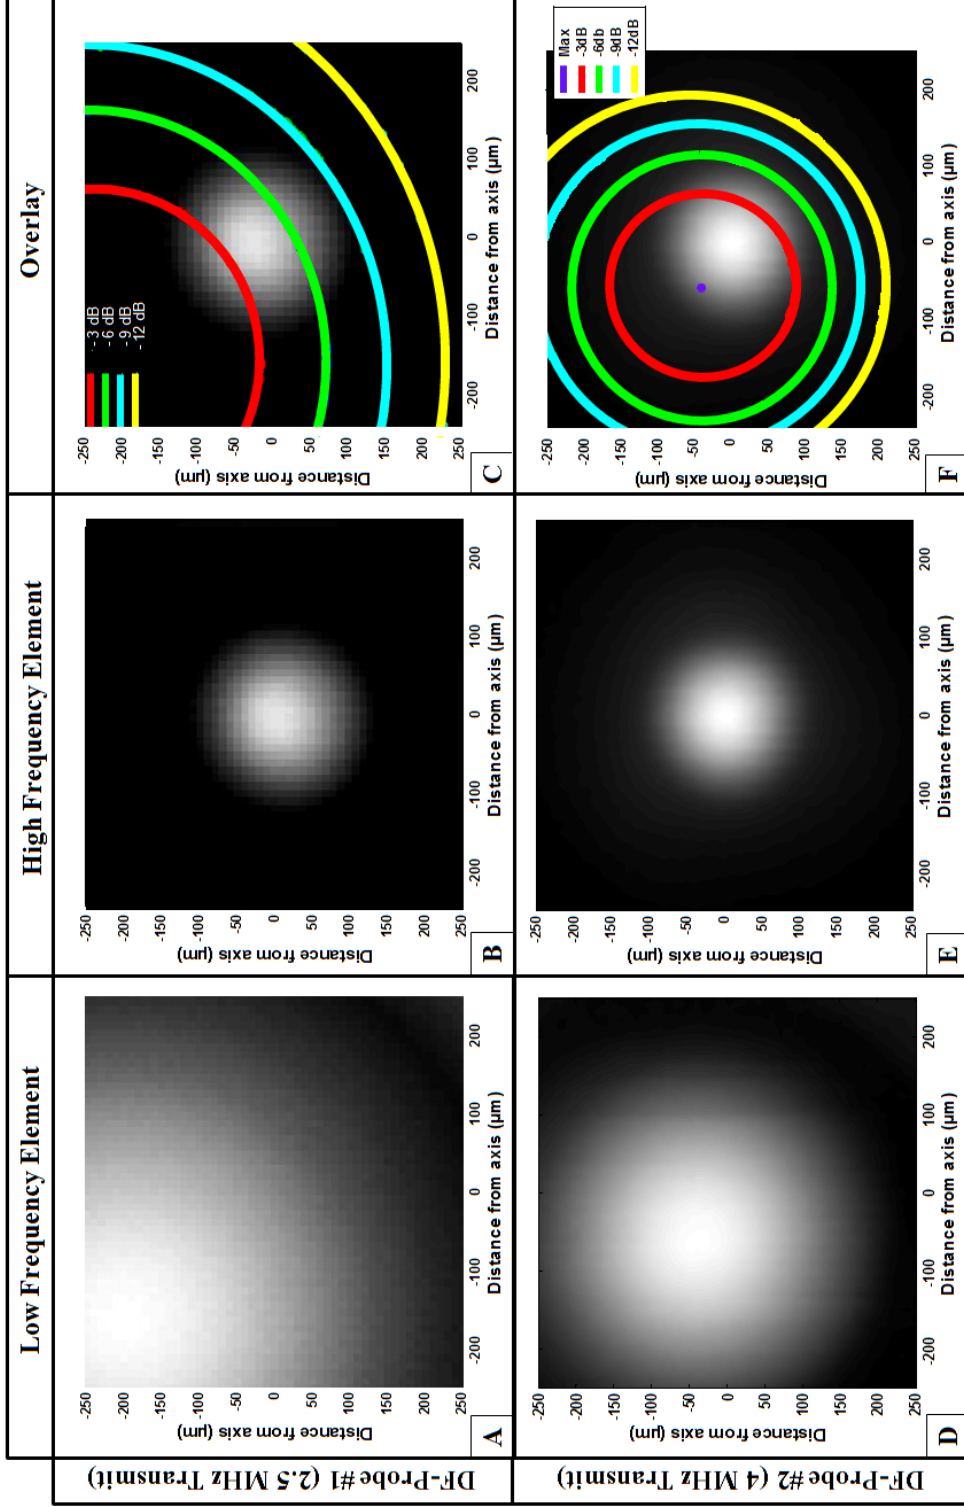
Beam field maps acquired centered around the acoustic focus of the 30 MHz element. Data from both the first (top) and second (bottom) generation dual-frequency ultrasound transducers. All data in this chapter was acquired with the first generation (2.5 MHz transmit). The second generation probe had a better alignment and an increase in pulsing frequency.
